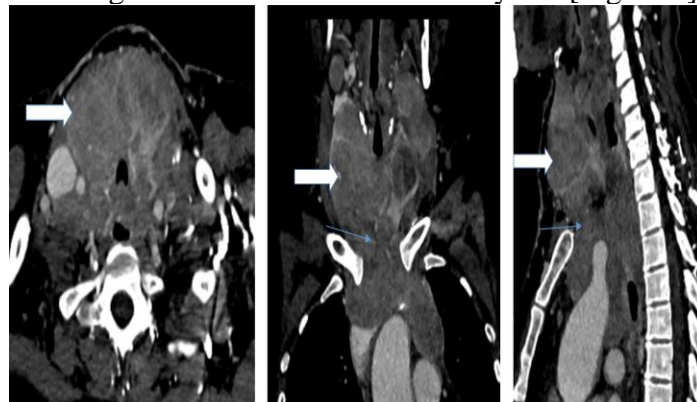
Axial contrast enhanced CT neck with coronal and sagittal reformation in venous phase demonstrates heterogeneously enhancing lesion (white arrow) involving both lobes and isthmus, which shows indistinct fat planes with mediastinal lymphadenopathy (blue arrow) in coronal and sagittal planes.
